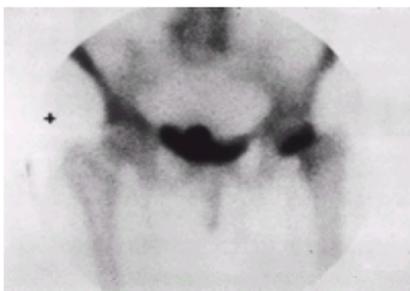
Osteoporotic stress fracture. Bone scan of a 72-year-old woman with normal hip radiographs and left groin pain. The scan reveals increased uptake of technetium in the left femur, evidence of a stress fracture at the junction of head and neck (+, right).
